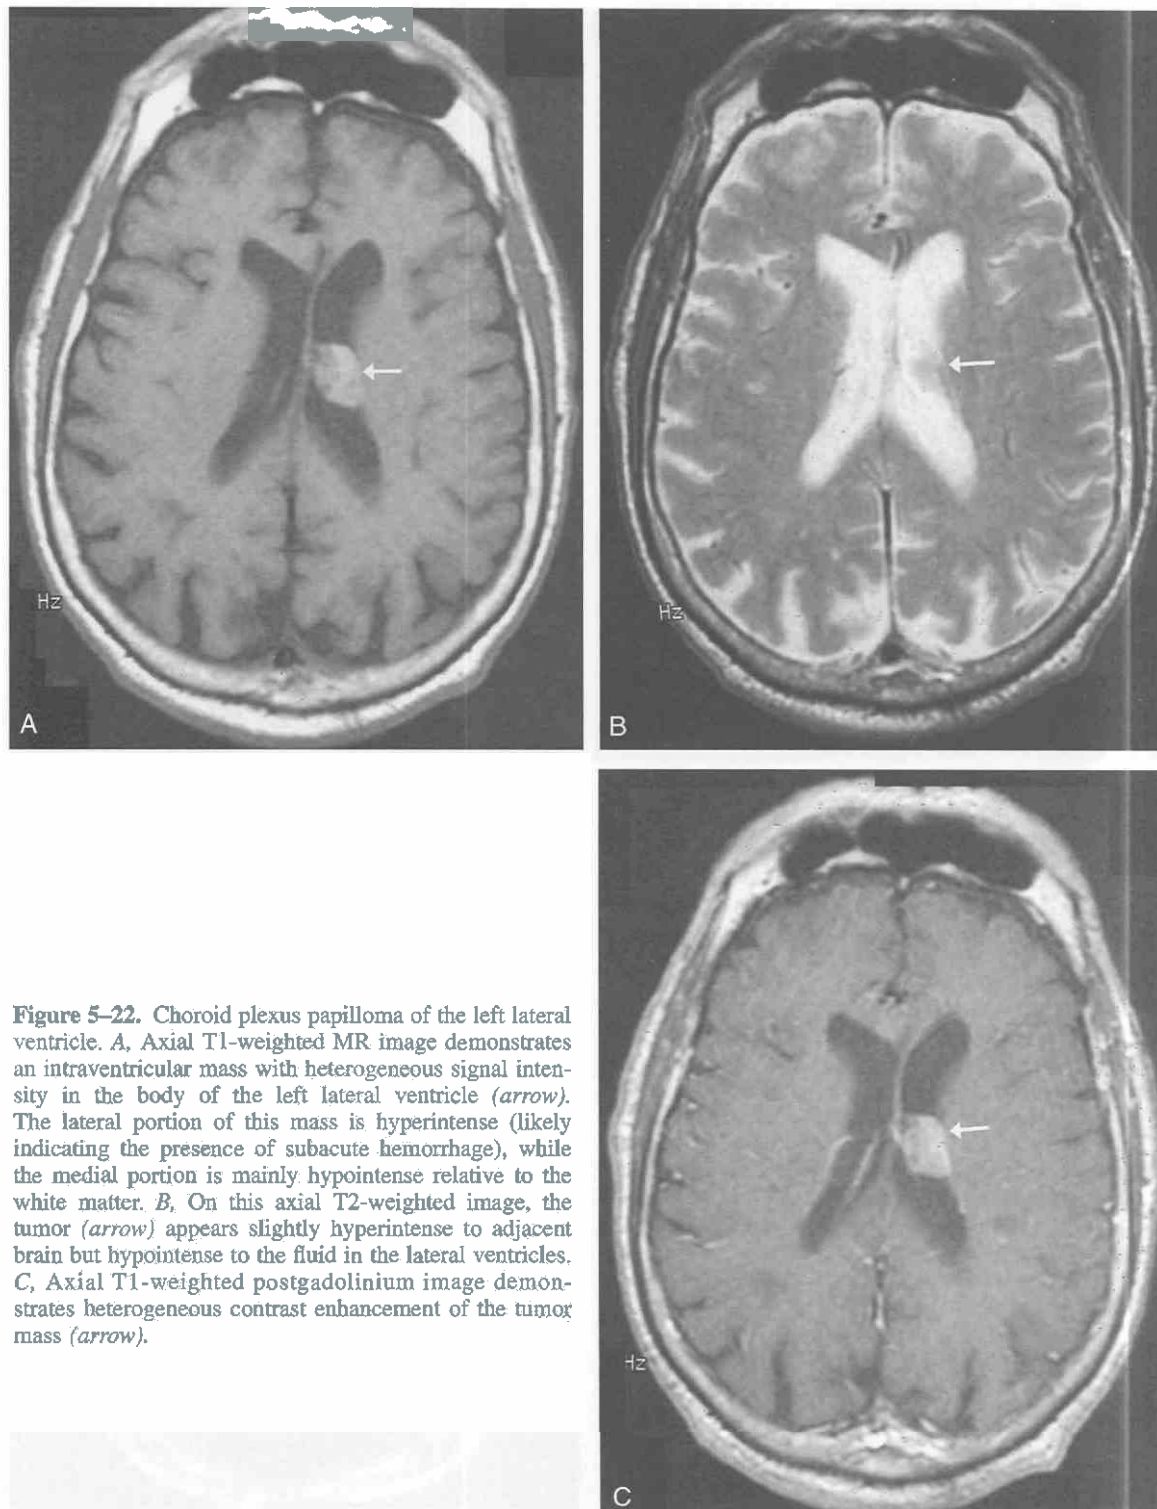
Choroid plexus papilloma of the left lateral ventricle. *A*, Axial T1-weighted MR image demonstrates an intraventricular mass with heterogeneous signal intensity in the body of the left lateral ventricle (arrow). The lateral portion of this mass is hyperintense (likely indicating the presence of subacute hemorrhage), while the medial portion is mainly hypointense relative to the white matter. *B*, On this axial T2-weighted image, the tumor (arrow) appears slightly hyperintense to adjacent brain but hypointense to the fluid in the lateral ventricles. *C*, Axial T1-weighted postgadolinium image demonstrates heterogeneous contrast enhancement of the tumor mass (arrow).
